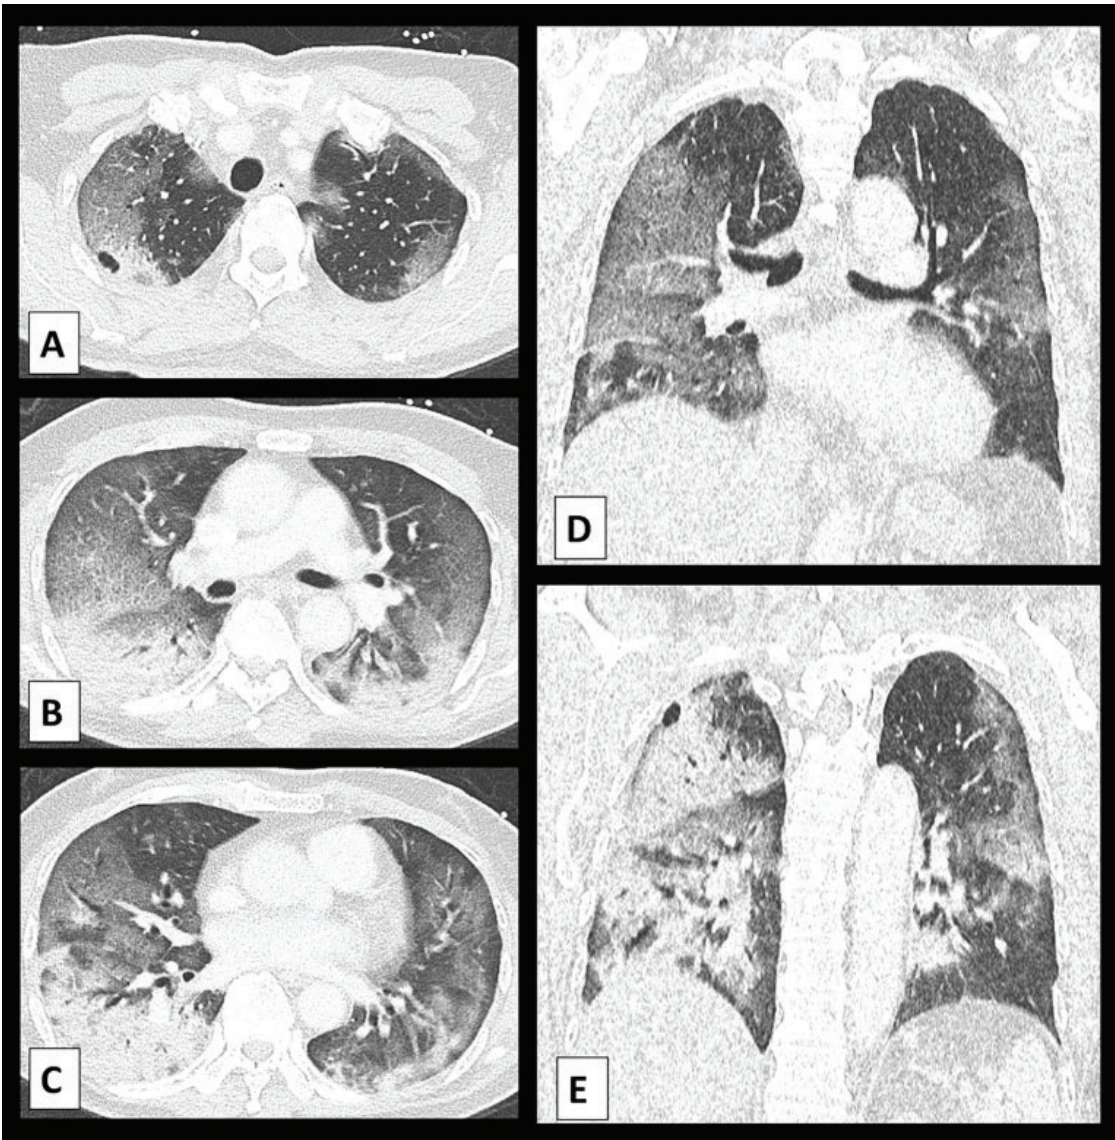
Computed tomography (CT) of lung. A: Axial contrast-enhanced CT image showed ground-glass opacities that predominate in upper lobes with stark thin rim of subpleural sparing. B: Axial CT image showed mild, smooth intralobular septal thickening that gave the appearance of “crazy paving”. C: Axial CT image showed consolidation in dependent segments of both lungs with an asymmetric distribution that involved predominantly the right lower lobe. D and E: Coronal CT images showed an incidental small, thin-walled subpleural cyst in right upper lobe that likely represents a pneumatocele. Neither intrathoracic lymphadenopathy nor pleural effusion was observed.
